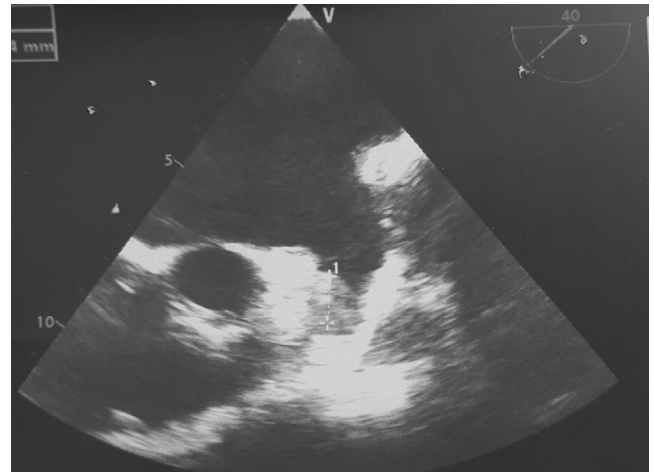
Transesophageal echo showing a clot lying well inside the LA appendage.
